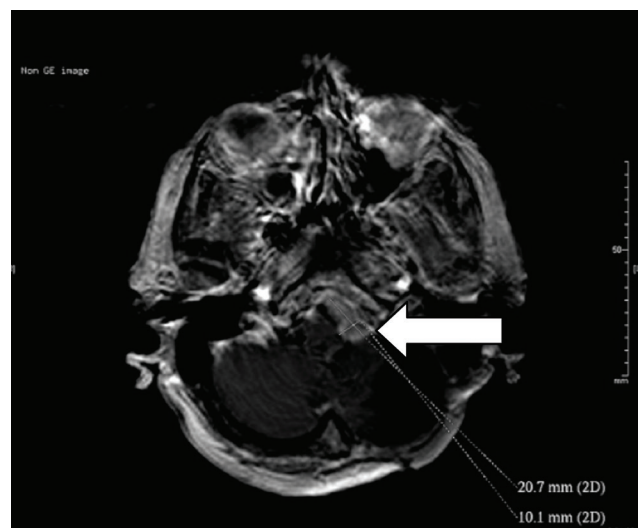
Post-SRS 3rd year follow-up axial MR images of the patient in Figure 1 showing lesion downsizing (arrow).
